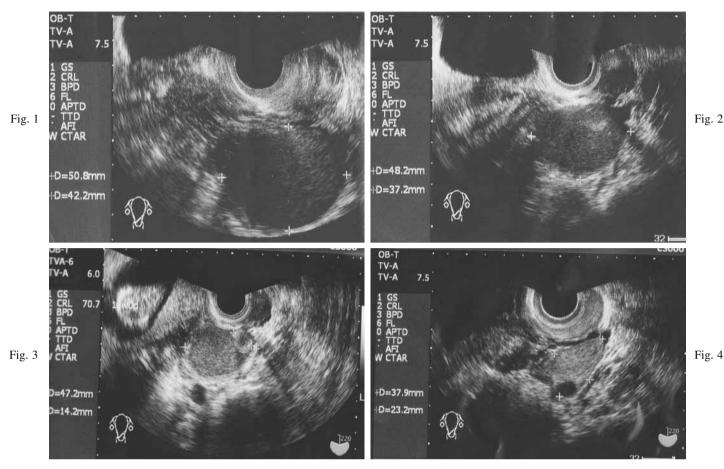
TV-ultrasonographic findings of the left ovarian endometriotic cyst three months before pregnancy.
